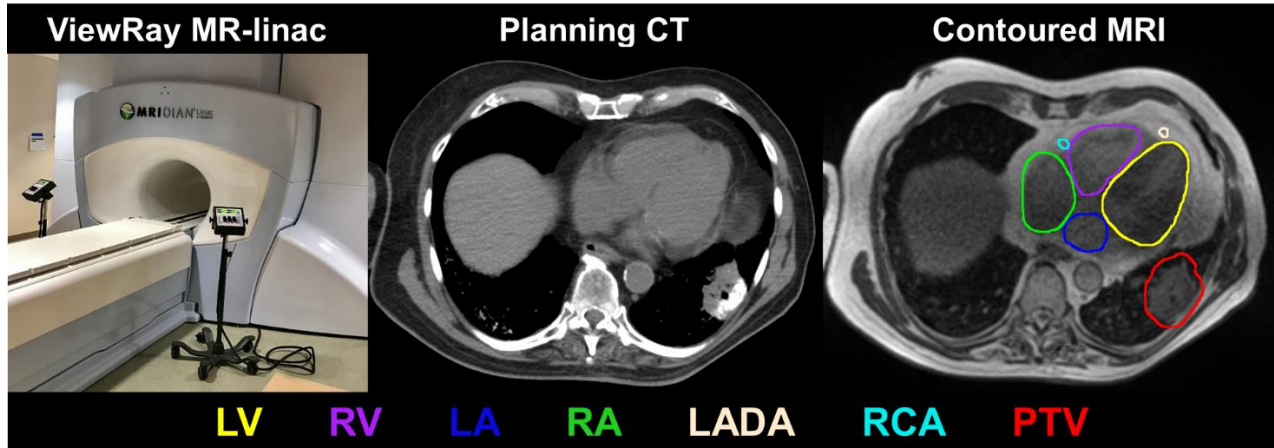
(Left) ViewRay 0.35T MR-linac, (Middle) treatment planning CT, (Right) 0.35T MR dataset with cardiac substructure contours evident and delineated. PTV: planning target volume (malignant neoplasm of lower left lung bronchus). Cardiac-related abbreviations are defined in the text.
